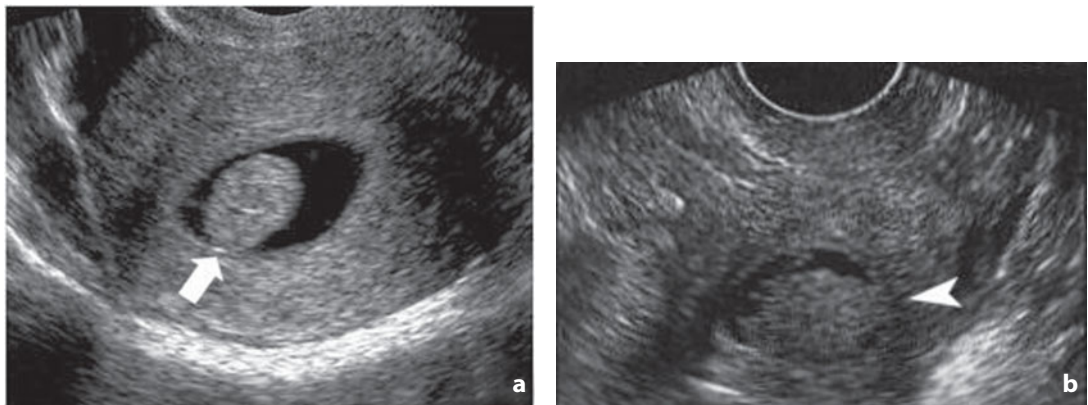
Hysterosonography. Endometrial polyp. a The lesion (*arrow*) projects into the lumen of the endometrial cavity which appears distended by fluid. b Another, larger, pedunculated lesion (*arrowhead*) with irregular margins occupying almost the entire endometrial cavity
